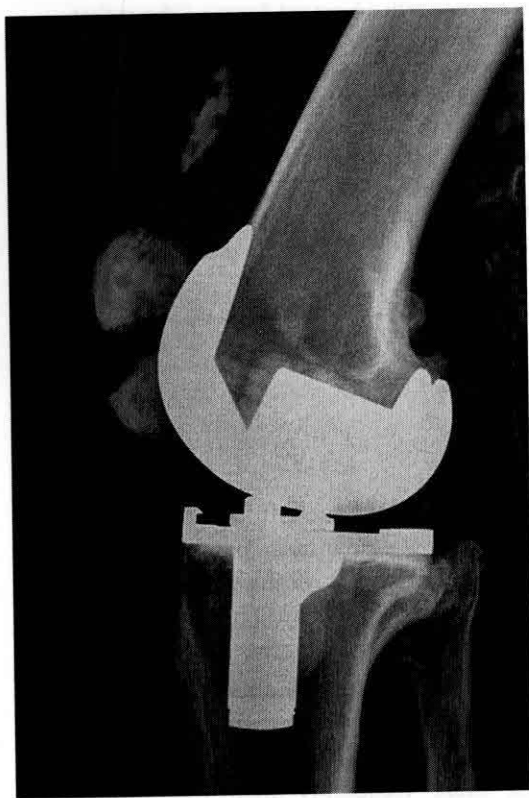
Lateral knee radiograph demonstrating patellar fracture after total knee arthroplasty.
